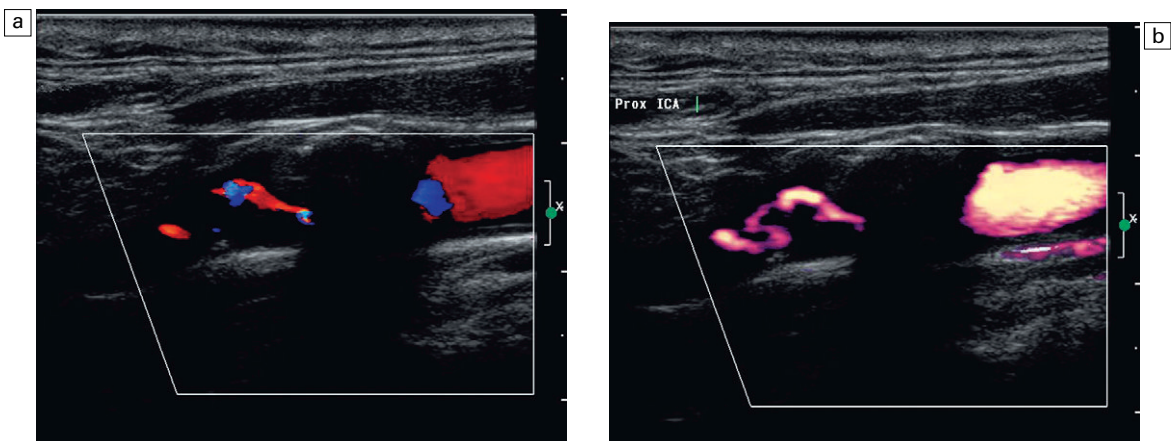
A thin residual channel on colour Doppler (a) and on power Doppler (b) which is more sensitive for weaker, slower signals and shows the tortuous residual lumen more clearly.
